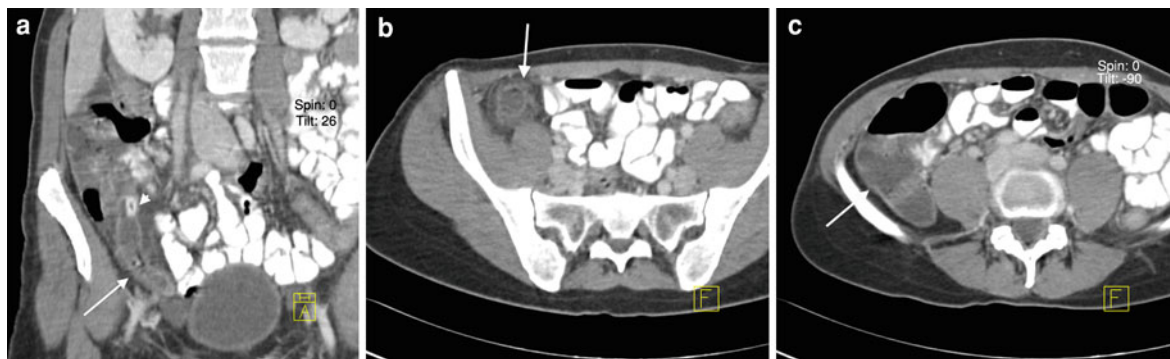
Patient with acute appendicitis. a Coronal CT image obtained with IV and oral contrasts showing enlarged, enhancing, and fluid-filled appendix (*long arrow*) and appendicolith (*arrowhead*). b Transverse CT image obtained with IV and oral
